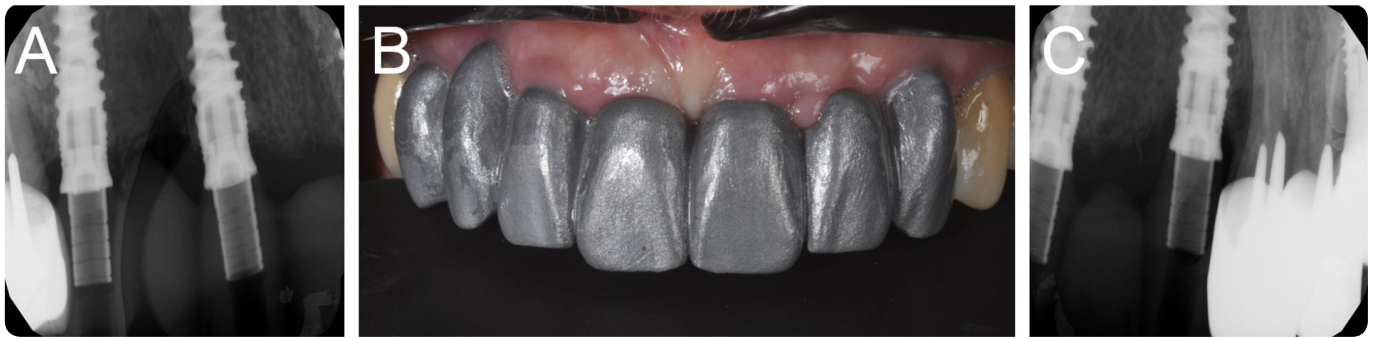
A replica of the final CAD project is milled in polyurethane hard resin and screwed intraorally to verify the passive fitting and the marginal adaptation. Intraoral radiographs are taken to verify the adaptation. (A) Radiographic image of the replica, implants in the right side. (B) The milled replica screwed intraorally. (C) Radiographic image of the replica, implants in the left side.
